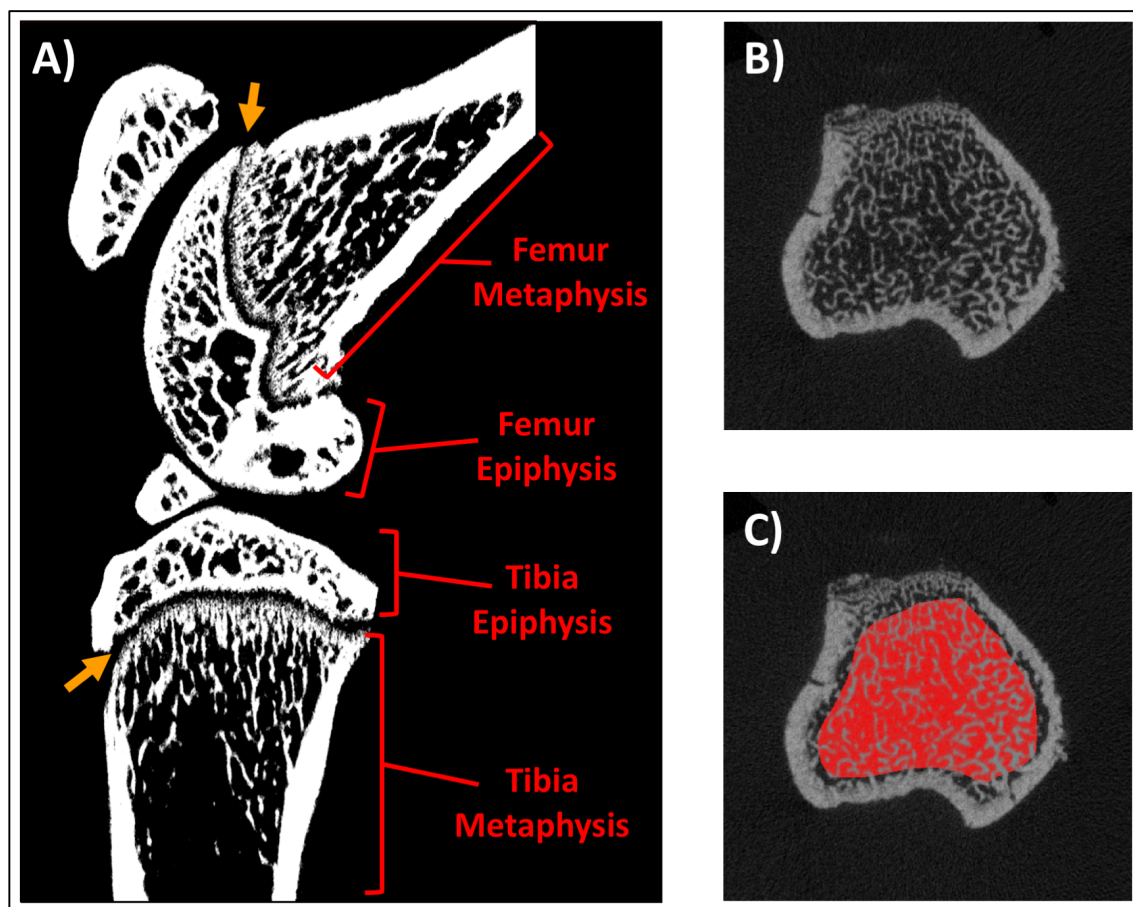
A) Four bone segments (femur metaphysis, femur epiphysis, tibia epiphysis, tibia metaphysis) were manually selected for bone morphological analyses. The epiphyseal plates are indicated by the arrows. B) A transaxial μ CT slice of a tibia metaphysis before and C) after ROI selection (shown in red). ROI were manually selected as to include only trabecular bone and to avoid cortical bone.
